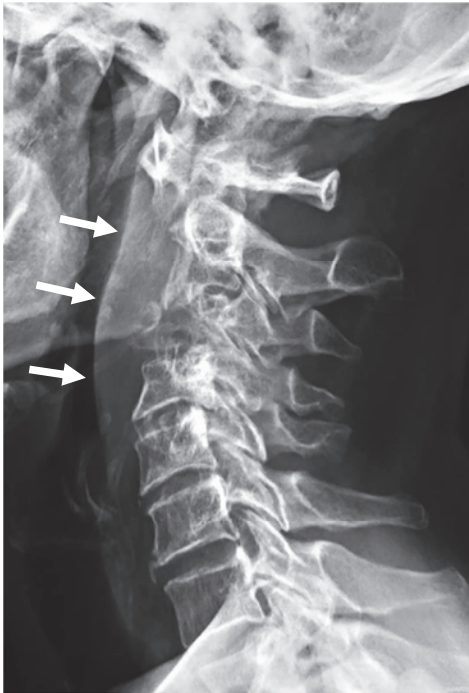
Tuberculous spondylitis of the cervical spine. Lateral radiograph shows compression of C3 vertebral body and marked thickening of the prevertebral soft tissues (arrows). Note the anterior atlanto-axial subluxation
